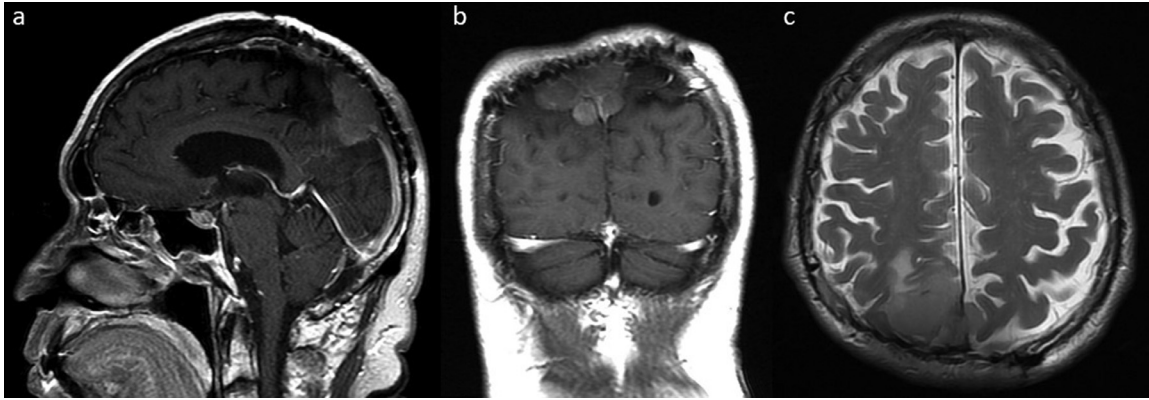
(a-c). Gadolinium-enhanced T1-weighted sagittal (a) and coronal (b) views as well as a T2-weighted axial view (c) of an MRI of the brain showed a multilobulated enhancing lesion along the parietal falx extending into the right parasagittal region. Surrounding low T1 signal intensity and high T2 signal intensity was increased since the prior study, representing worsening cerebral edema. There was increased mass effect on the right posterior horn of the right lateral ventricle. The mass at this time measured 3.4 x 4.7 x 5.4 centimeters (on the prior, it had measured 3.7 x 3.2 x 4.2 centimeters). Paracentrally, there was diffusion restriction noted within the tumor. At the level of the tumor, the superior sagittal sinus showed no evidence of flow void; this was strongly suggestive that the tumor had invaded the sagittal sinus
